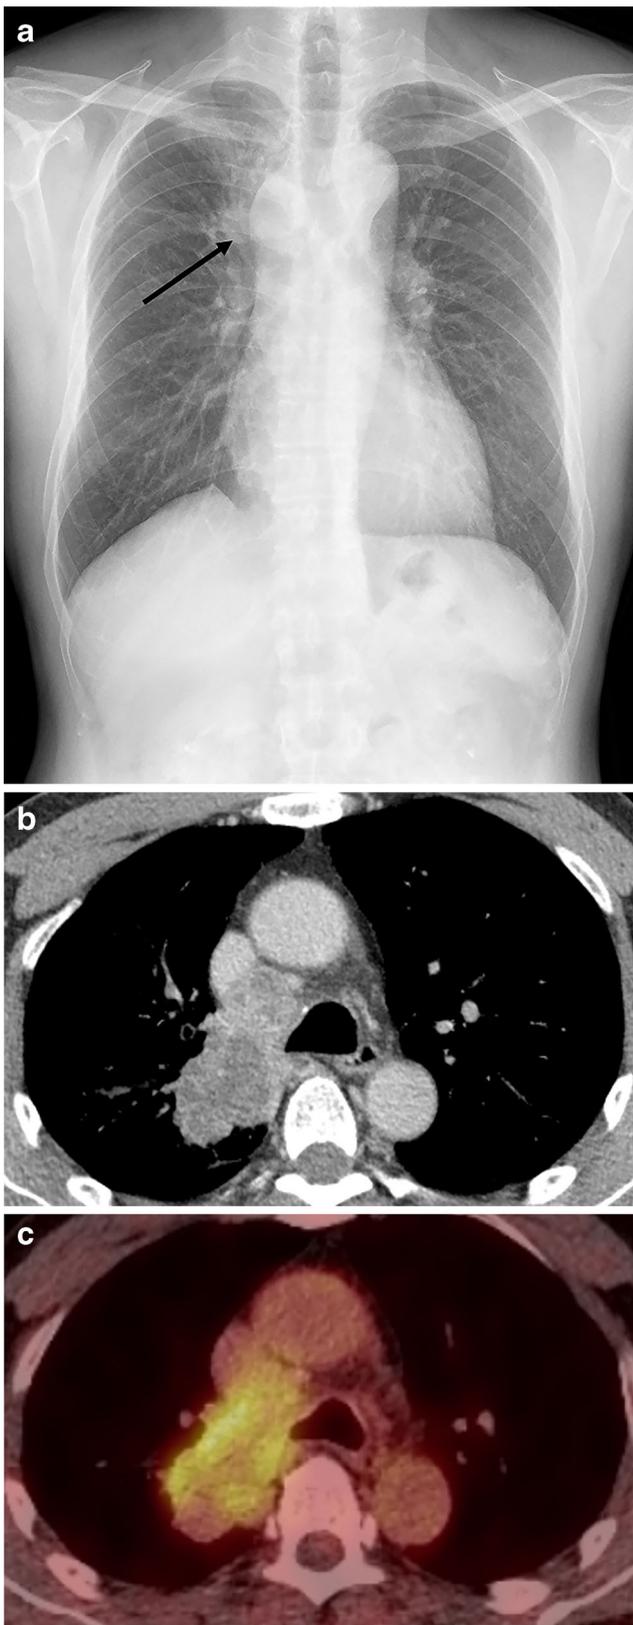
A representative case of initial recurrence in the thorax which was beyond the coverage of abdominal CT. a Chest radiograph taken 59 months after the operation demonstrated a bulging opacity at the right paratracheal area (black arrow). b On chest CT taken on the same day of the chest radiograph, an approximately 4.8-cm mass on the right upper lobe and lymph node enlargement at the right paratracheal area were detected without any metastasis in the abdomen and lower thoracic area. c Additionally, performed PET-CT revealed hyper-metabolism at the right upper lobe lesion and the right paratracheal lymph node. Cytology by bronchoscope confirmed these lesions as metastatic adenocarcinoma from the colon
